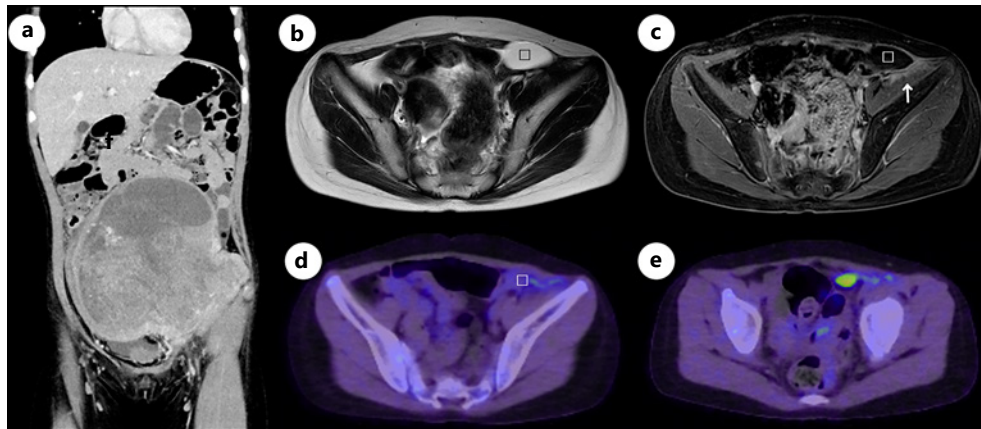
a Contrast-enhanced CT before chemotherapy and tumor resection. The enlarged tumor was 14 cm × 13 cm in the abdominal pelvis. b MRI after tumor resection and postoperative chemotherapy shows a cystic lesion (33 mm, indicated as □) with high signal intensity on T2-weighted images and (c) low signal intensity on gadolinium-enhanced T1-weighted images, and this cystic lesion infiltrates the ventral side of the left iliac muscle (indicated arrow). d, e PET-CT after tumor resection and postoperative chemotherapy shows increased FDG uptake around the caudal side of the cystic lesion where it is in contact with the left iliac muscle (SUV max 3.4). MRI, magnetic resonance imaging; PET-CT, positron emission tomography-computed tomography; FDG, fluorodeoxyglucose; SUV, standardized uptake value; □, cystic lesion.
